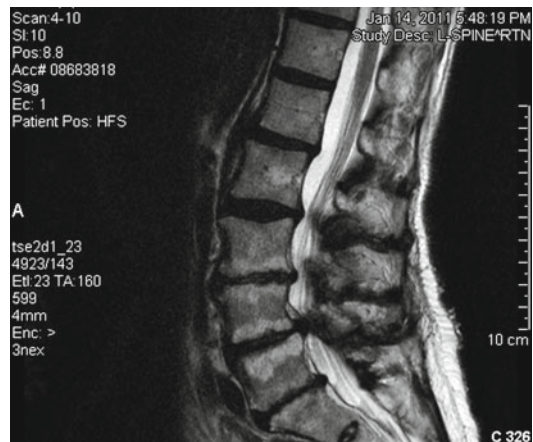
Sagittal T2 MRI demonstrating spinal stenosis
